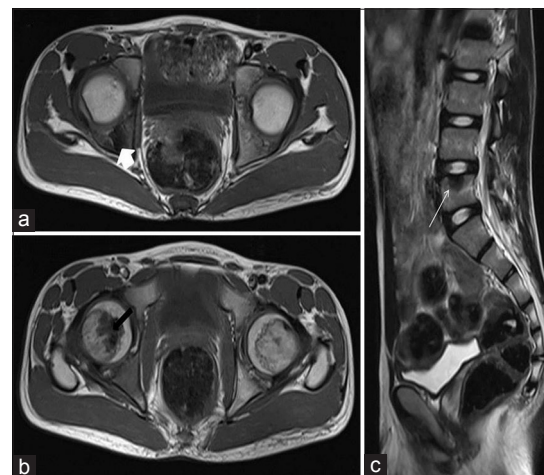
A 15-year-old child with synchronous MOGS-non-contrast T1-weighted axial MR images of bilateral hip (a and b) and T2-weighted sagittal images of lumbar spine (c) revealed hypointense lesion (black arrow) involving head of femur, posterior wall of acetabulum (white arrow), and L5 vertebral body (white line arrow), respectively. MOGS = Multifocal osteogenic sarcoma, MR = Magnetic resonance
